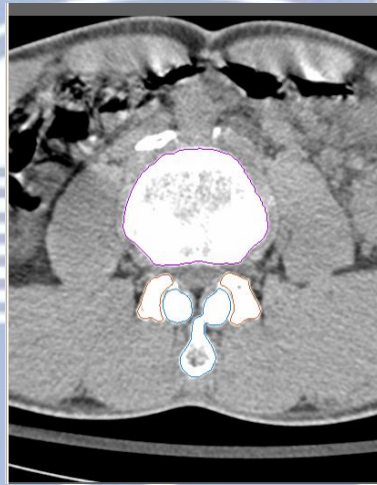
1: Each spinal component was selected from computed tomography scan DICOM file to create material-related contours.
